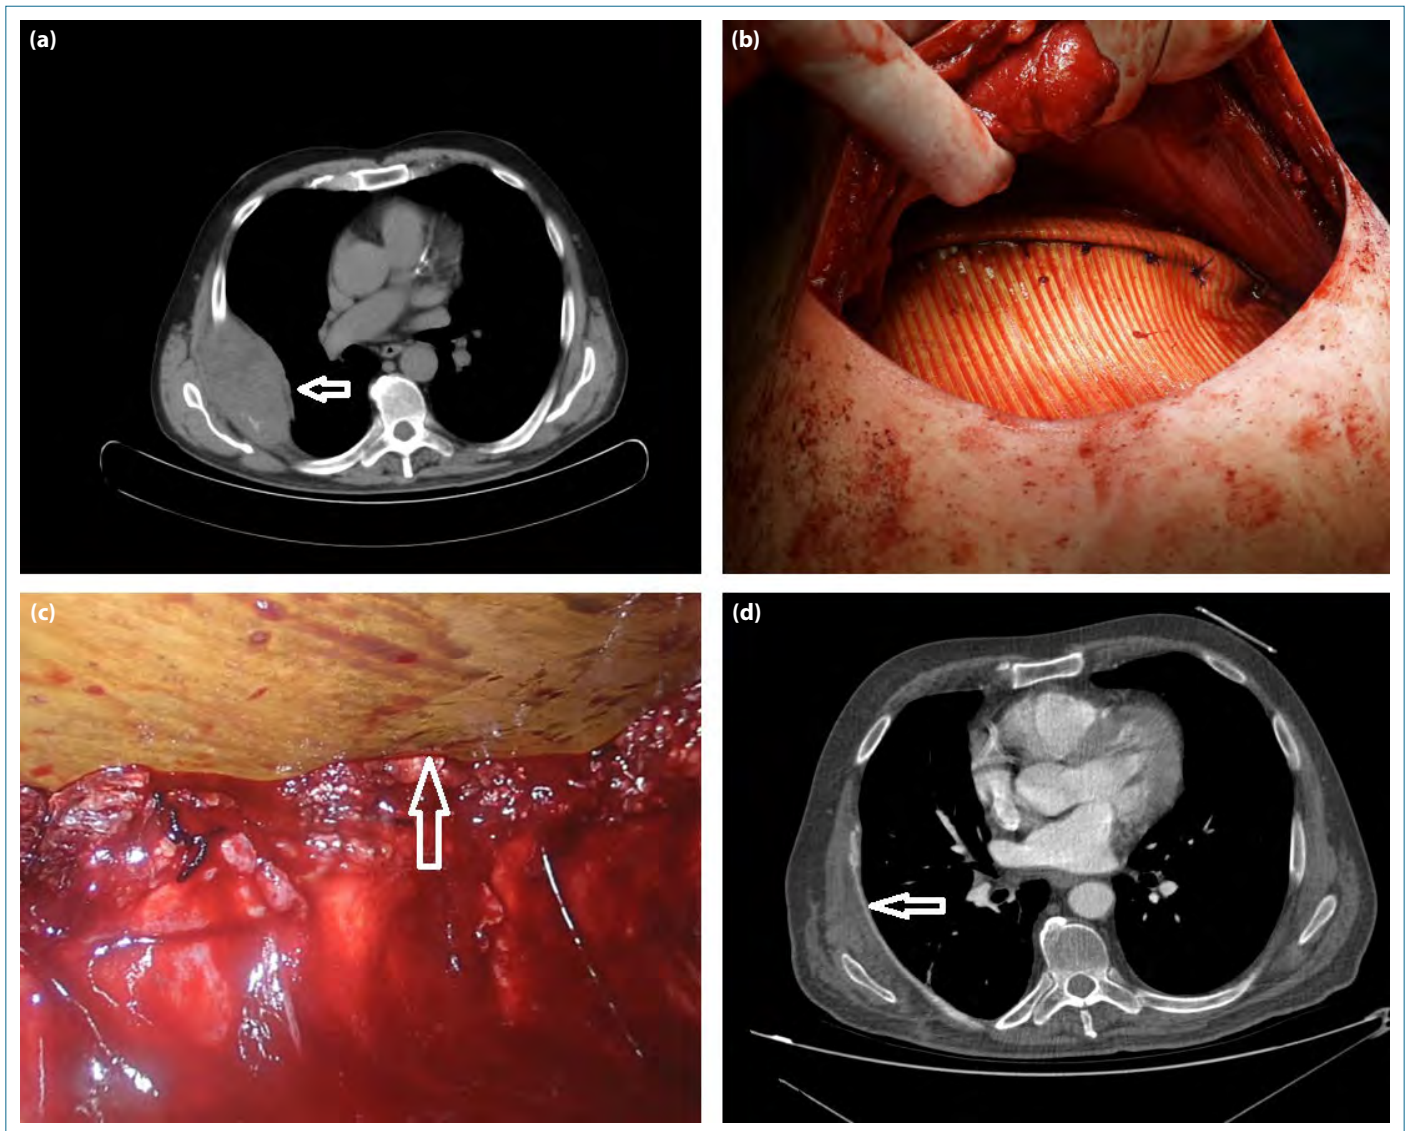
(a) Preoperative CT image of the patient, (b) intraoperative appearance of the PTFE prosthesis, (c) intraoperative thoracoscopic image of the patient, (d) CT image showing the prosthesis.
